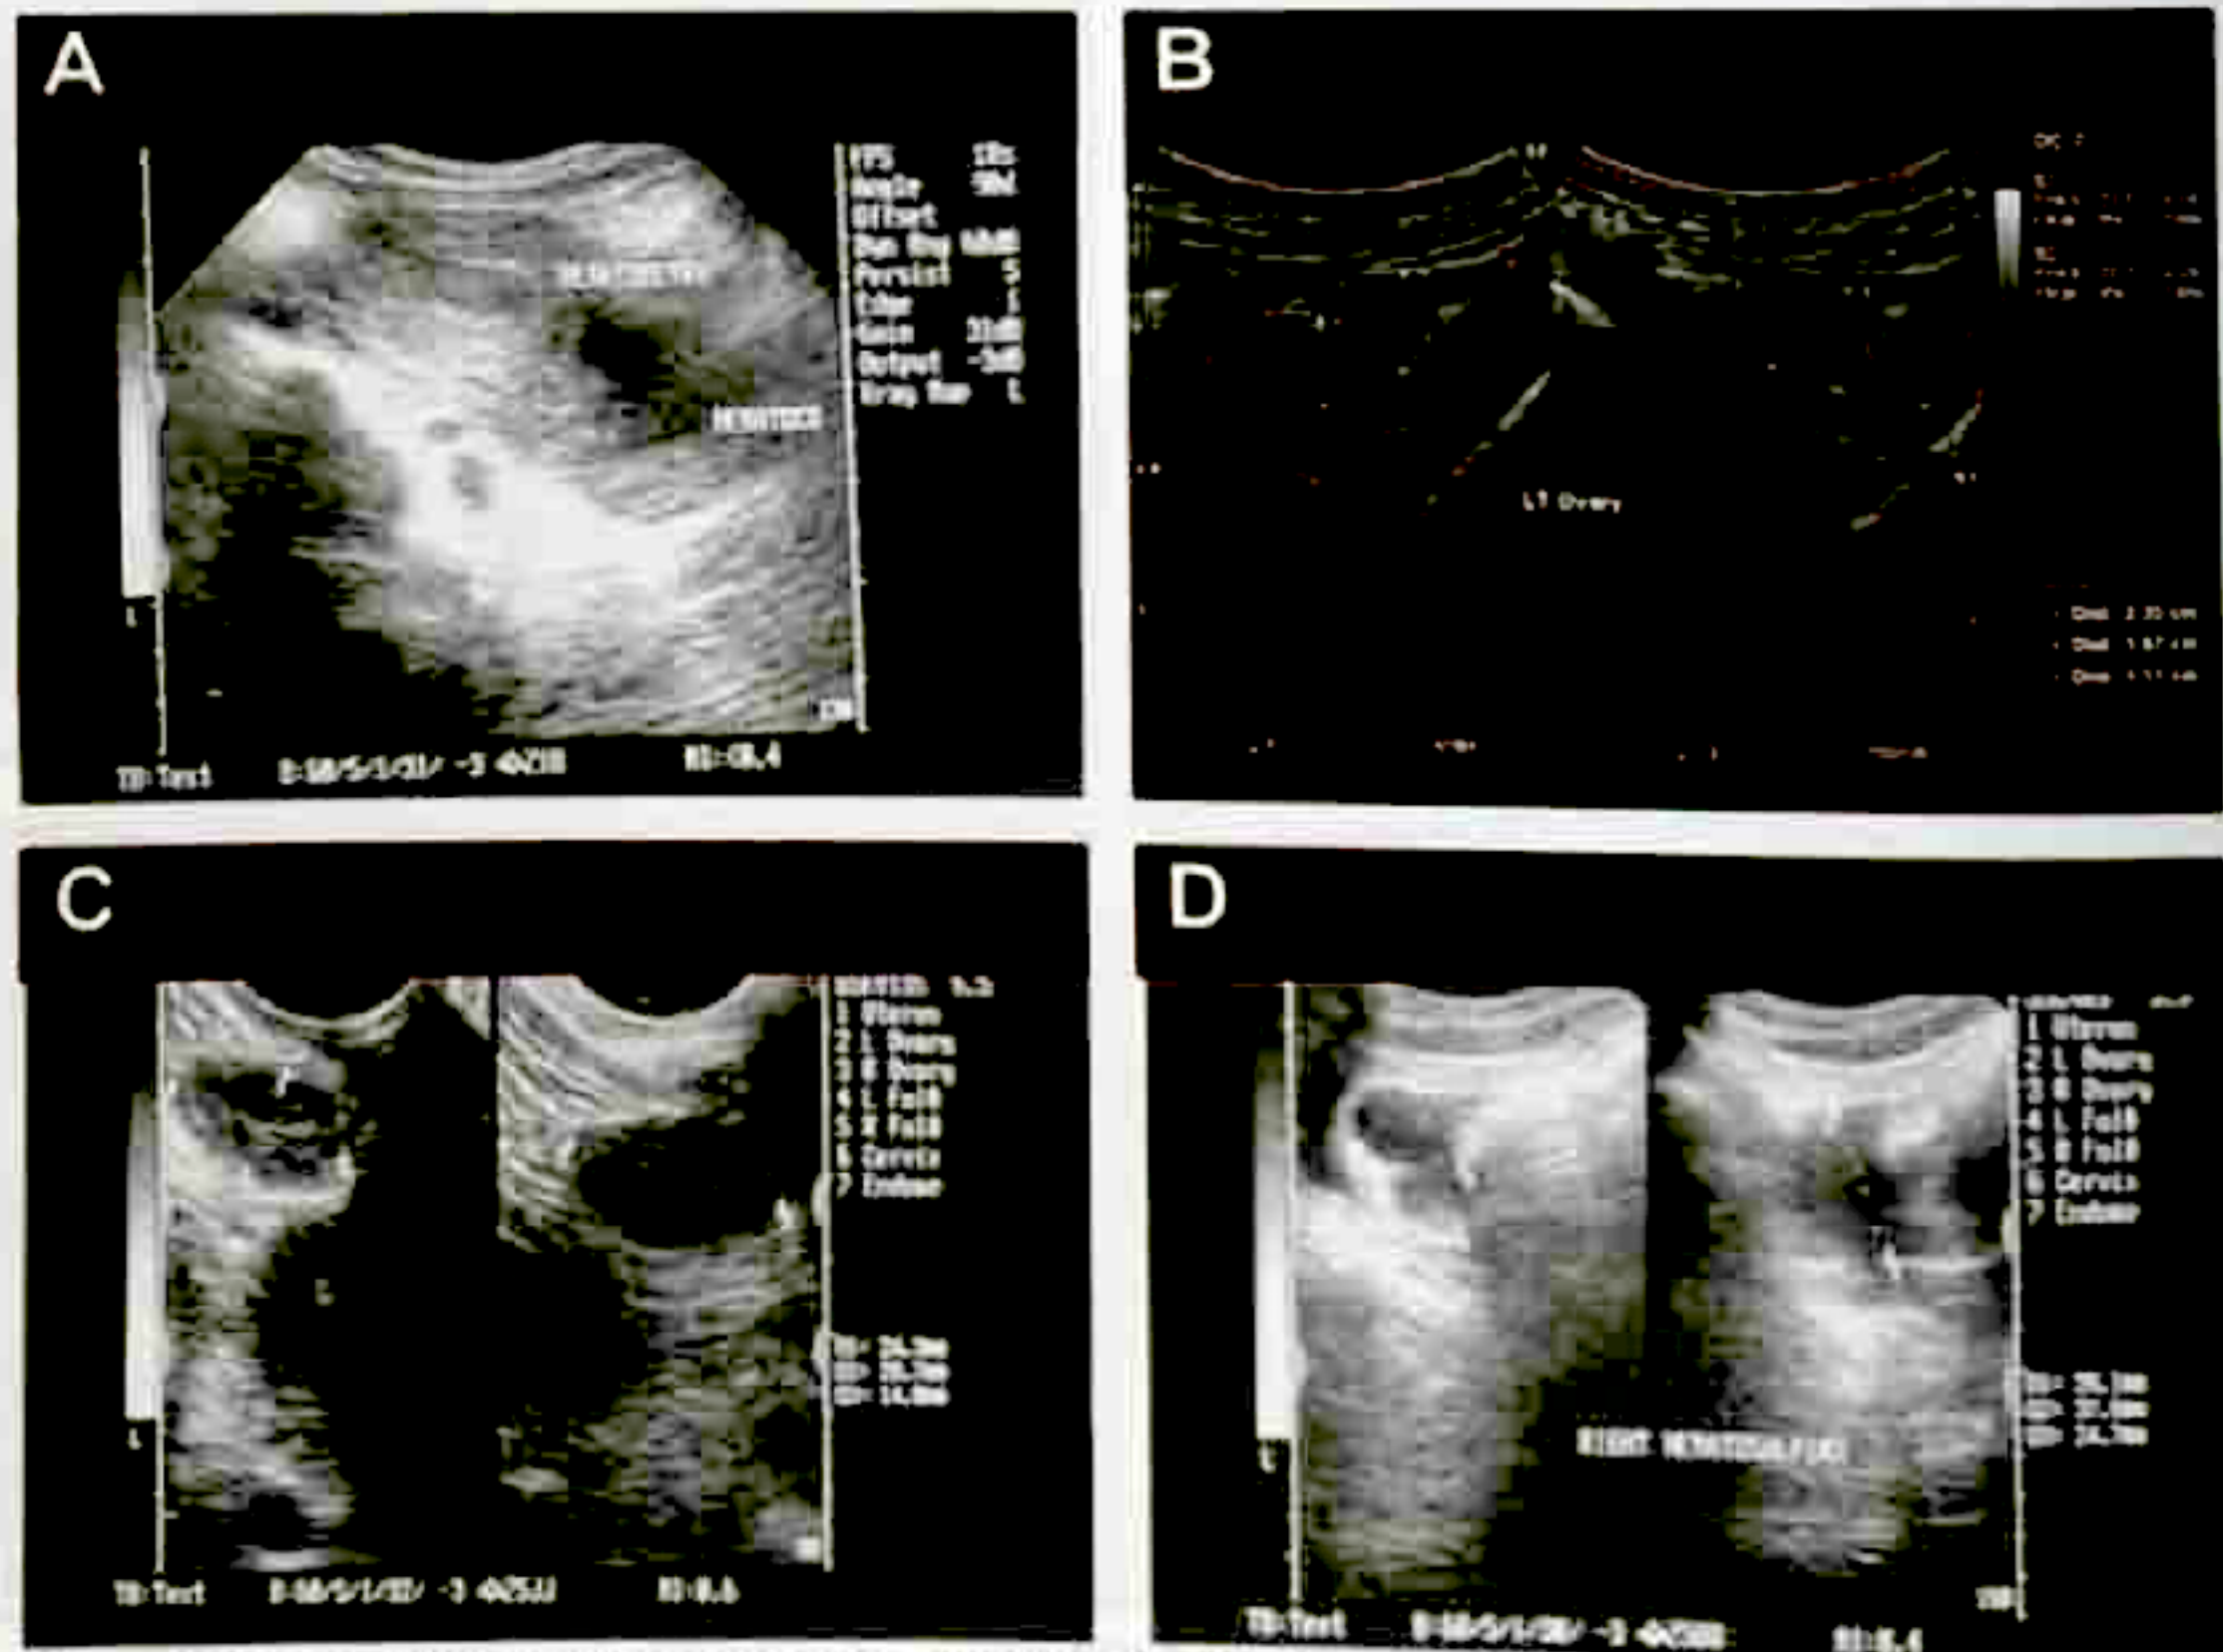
Transabdominal ultrasound of second index patient on re-admission. A) Hemato-colpometra. B) Left ovary. C) Right endometriotic cyst. D) Right hematosalpinx.
